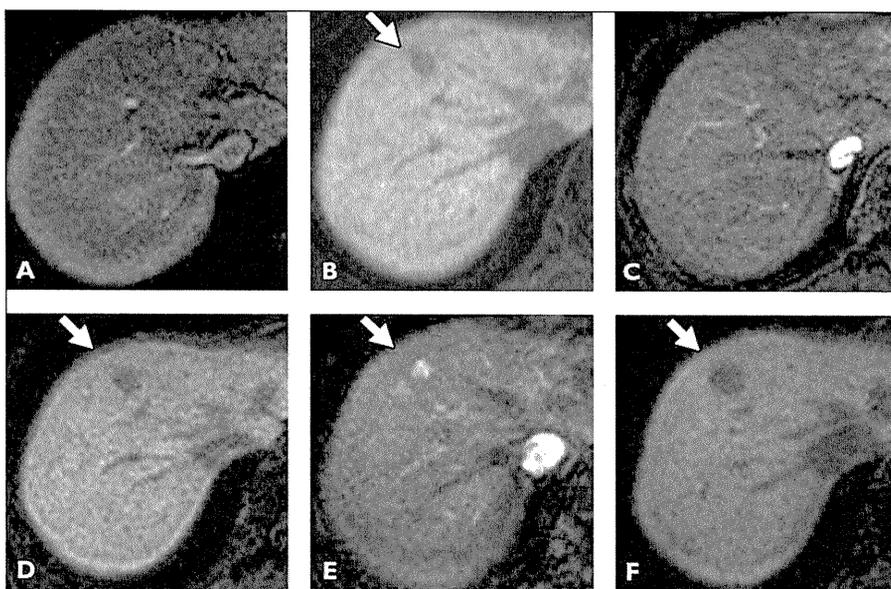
75-year-old man with hepatitis C-related cirrhosis. A, Arterial phase gadoxetate disodium-enhanced MR image at start of follow-up shows no nodules. B, Hepatobiliary phase gadoxetate disodium-enhanced MR image at start of follow-up shows slightly hypointense nodule (arrow). C, Arterial phase dynamic gadoxetate disodium-enhanced MR image 9 months after start of follow-up shows no nodules. D, Hepatobiliary phase gadoxetate disodium-enhanced MR image 9 months after start of follow-up shows markedly hypointense nodule (arrow). E, Arterial phase gadoxetate disodium-enhanced MR image 15 months after start of follow-up shows hyperattenuating foci in nodule (arrow). F, Hepatobiliary phase gadoxetate disodium-enhanced MR image 15 months after start of follow-up shows markedly hypointense nodule (arrow).
